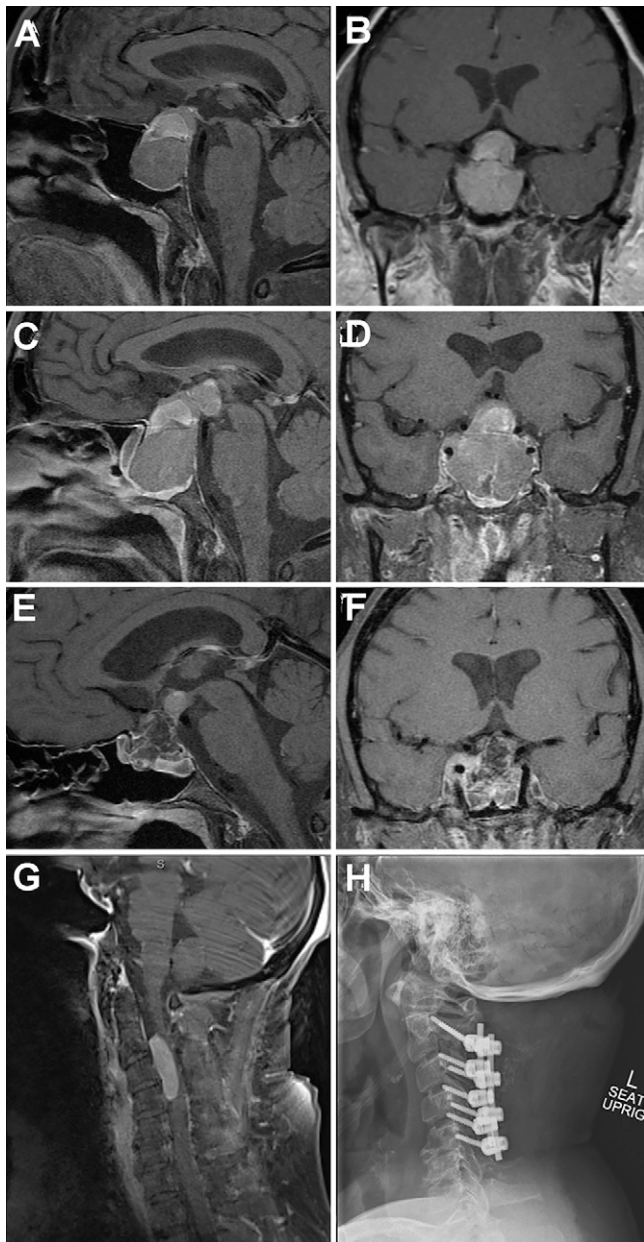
A and B: Preoperative MRI. Sagittal (A) and coronal (B) T1-weighted pituitary MRI with contrast shows sellar and suprasellar solid and cystic mass (2.3 × 2.8 × 4.0 cm) with hypothalamic indentation, superior displacement of the optic chiasm, and surrounding vasogenic edema. C–F: MRI of the pituitary gland. Sagittal (C) and coronal (D) T1-weighted pituitary MRI scans with contrast obtained after initial resection show blood products and fluid levels within the sellar mass, increased mass effect along the hypothalamus with partial effacement of the third ventricle, and bilateral cavernous sinus invasion with partial encasement of bilateral internal carotid arteries. Sagittal (E) and coronal (F) T1-weighted pituitary MRI scans with contrast obtained after repeat resection of invasive prolactin-secreting pituitary macroadenoma with fat and fascia graft packing in the sphenoid sinus and sella turcica. There is a small amount of residual enhancing tumor along the hypothalamus and at the floor of the third ventricle and incomplete encasement of the right internal carotid artery without narrowing.
